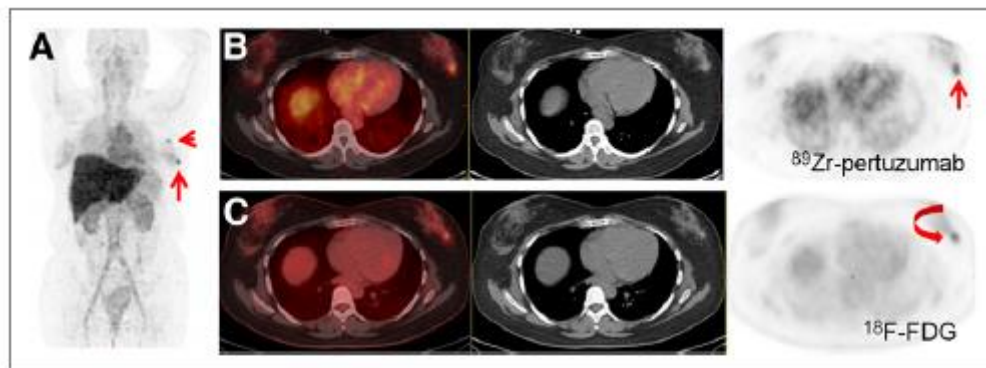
58-y-old woman with HER2-positive breast cancer and current left breast and left axillary nodal disease. (A) Maximum-intensity-projection image 6 d after administration of ^{89}Zr -pertuzumab demonstrated ^{89}Zr -pertuzumab-avid left breast (arrow) and left axillary nodal (arrowhead) disease. (B) Axial fused PET/CT, CT, and PET images obtained 6 d after ^{89}Zr -pertuzumab administration localized ^{89}Zr -pertuzumab avidity in left breast (arrow). (C) Axial fused PET/CT, CT, and PET images from ^{18}F -FDG PET/CT scan 3 wk earlier demonstrated corresponding ^{18}F -FDG-avid breast lesion (arrow).
